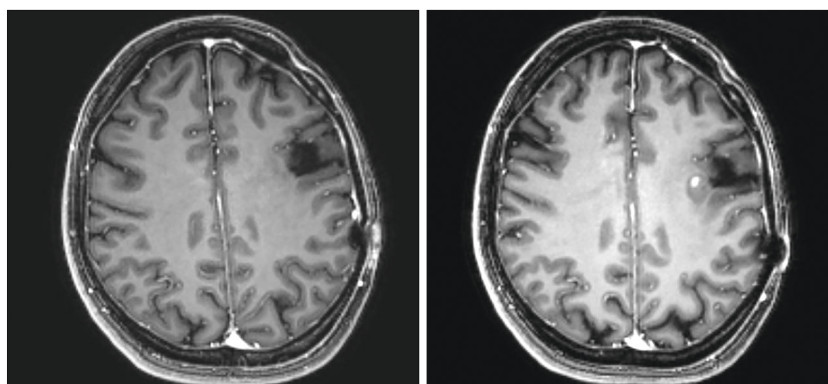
Postoperative FU contrast enhanced T1-weighted MRI scans of the patient showed in Figure 1. No contrast enhancement is present on the MRI performed 13 months after the surgery (left). Malignant transformation appeared on FU MRI scans 25 months after the surgery (right) – the MT is represented by the new contrast enhancement.
